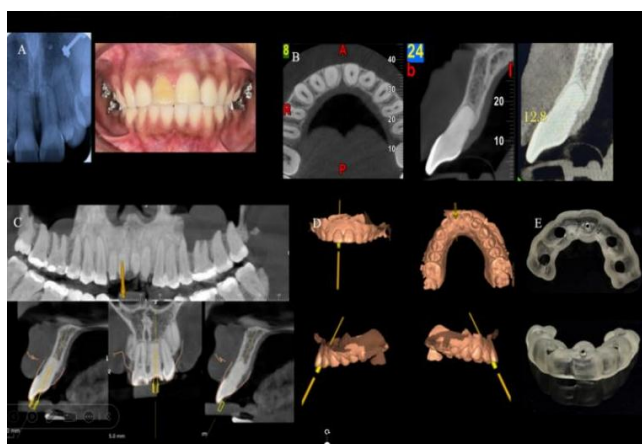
A: radiograph and discoloration in 11, B: A CBCT image showing canal obliteration, C: 3D guide planning D: 3D model of oral cavity, E: 3D printed surgical guide
